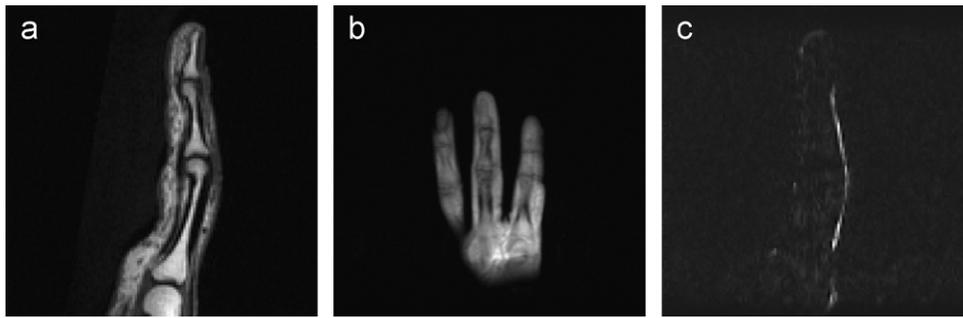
(a) Original MR image of the human finger in the vertical direction; (b) original MR image of the human finger in the lateral direction; and (c) original MR image of the blood flow in the human finger.
